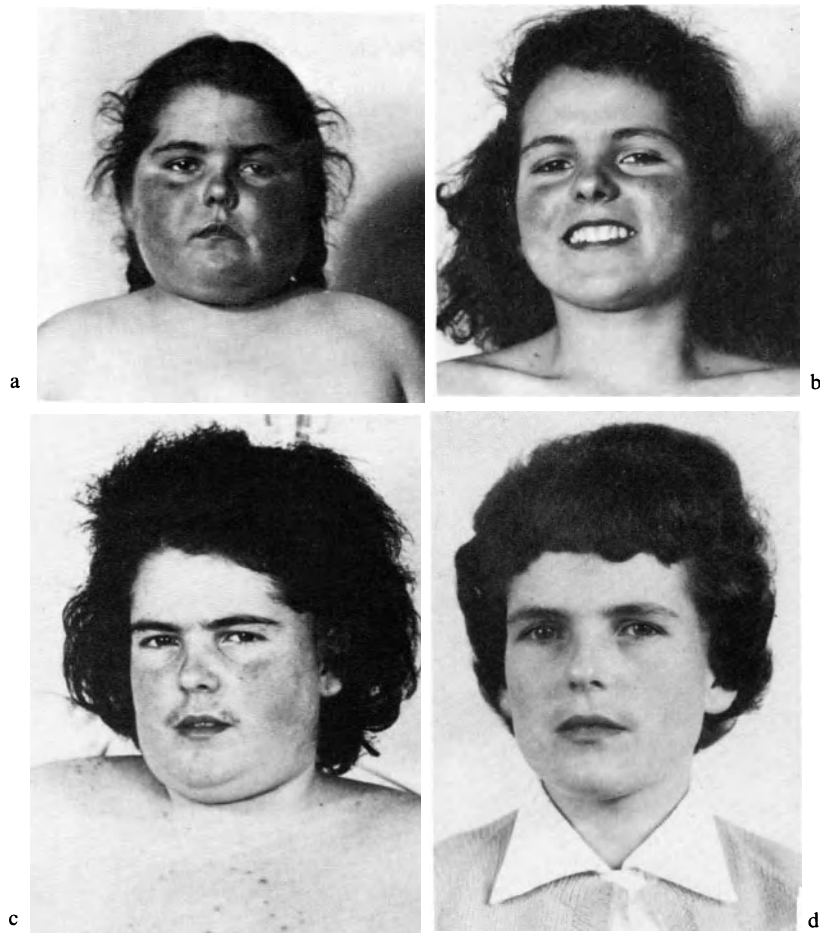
a) 12-year-old girl with Cushing's syndrome. Arrest of growth and truncal obesity, hypertension 200/120 mm Hg. b) 10 months following X-ray irradiation of the pituitary with complete remission. c) Severe relapse with multiple spontaneous vertebral fractures 9 years later. d) The patient one year after total adrenalectomy (a and b KspZ)
